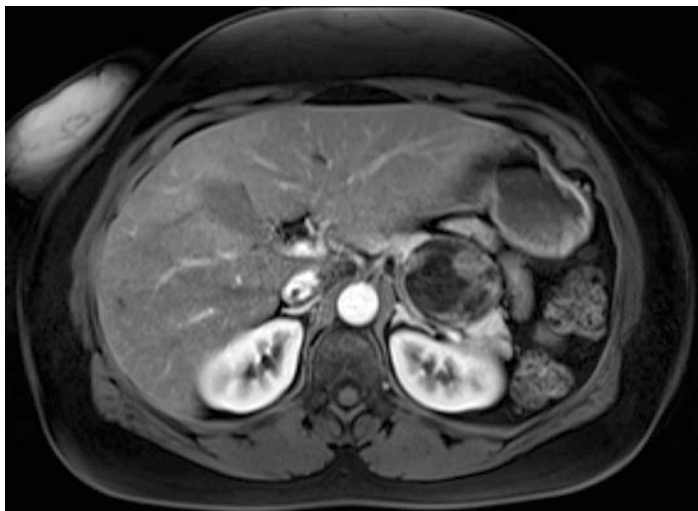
SPN on MRI imaging, showing a large T2 heterogenous, well-circumscribed mass, in the distal body/tail of the pancreas
